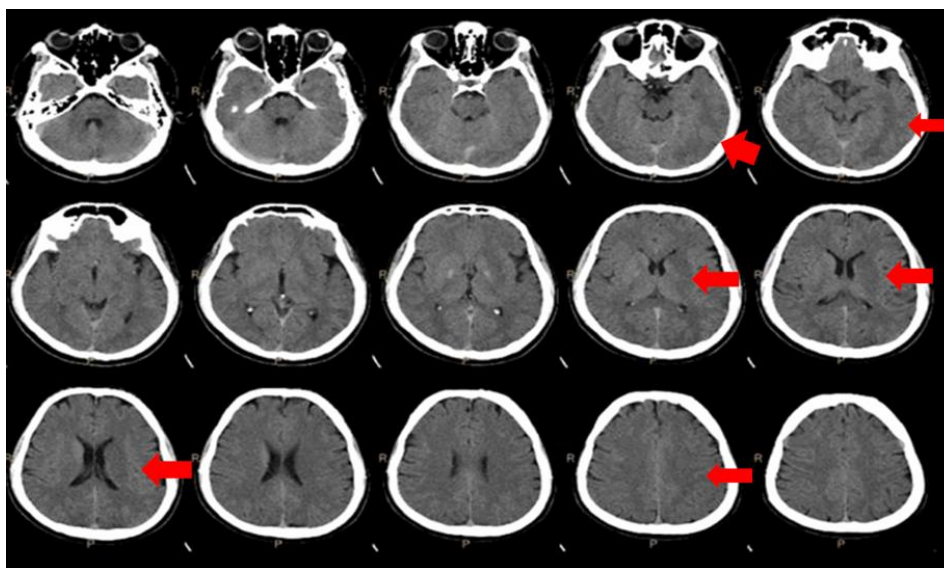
Neuroimaging via non-contrast head CT showed a broad hypodense area in the left middle cerebral artery territory (red arrow)
